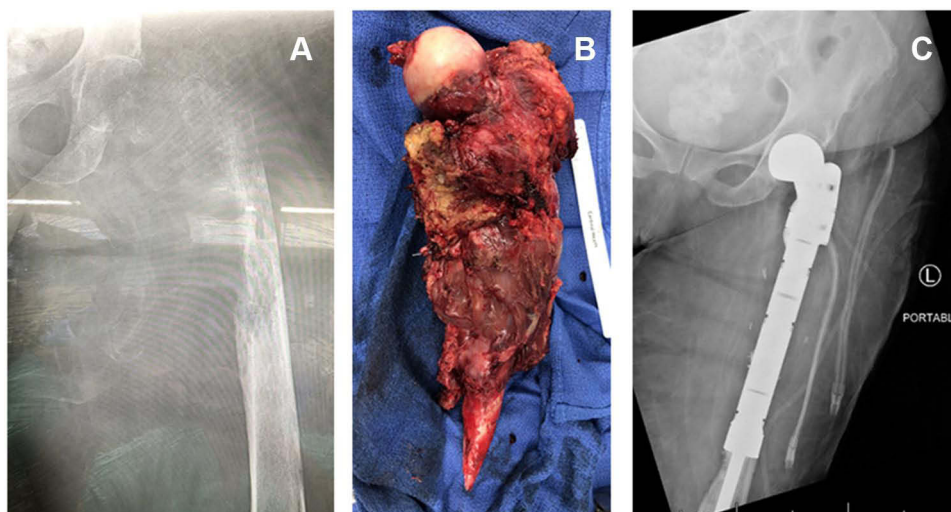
Patient with metastatic breast cancer presented complaining of left Hip pain. (A) Initial plain radiographs showed diffuse proximal femoral bone destruction. (B) The patient underwent proximal femur resection due to invasive metastatic lesion compromising the entire proximal femur. (C) Plain radiographs after final management with proximal femur replacement.
